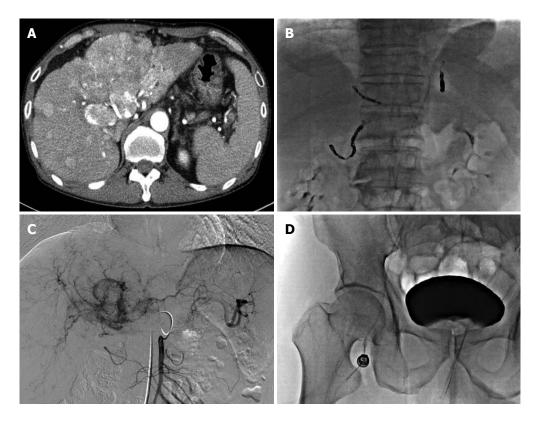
Technical aspects of hepatic artery infusion chemotherapy. A: Liver dynamic computed tomography showing multinodular hepatocellular carcinoma (HCC) with portal vein thrombosis; B: The embolization of non-target vessels to minimize the flow of chemotherapeutic agents into both uninvolved liver parenchyma and extrahepatic tissues; C: After finding HCC in the feeding artery, the tip of the catheter was located at the proper hepatic or common hepatic artery, chemotherapeutic agents were infused through a pump; D: The proximal end of the catheter was connected to the injection port, which was implanted in a subcutaneous pocket in the right iliac fossa.
